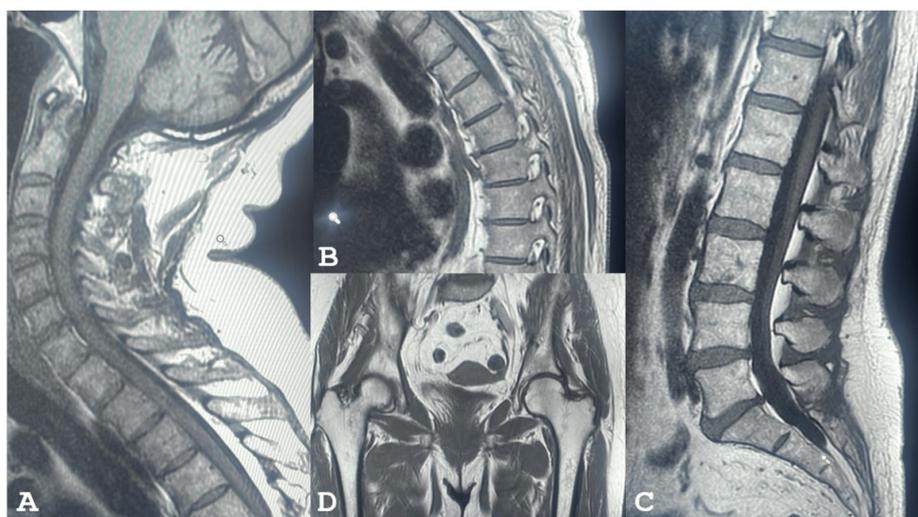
Magnetic Resonance Imaging. Spinal column and pelvis magnetic resonance imaging was negative: A. cervical segment, B. thoracic segment, C. lumbar and sacral segment, D. pelvis.
